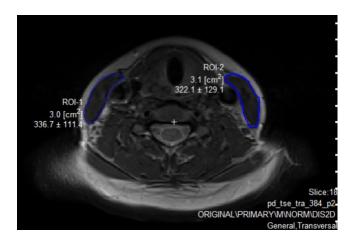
PC-MRI slice image of ROI analysis in Medvisio Segment program of SCMM to measure cross-sectional area to produce SCMM volume measurements.
